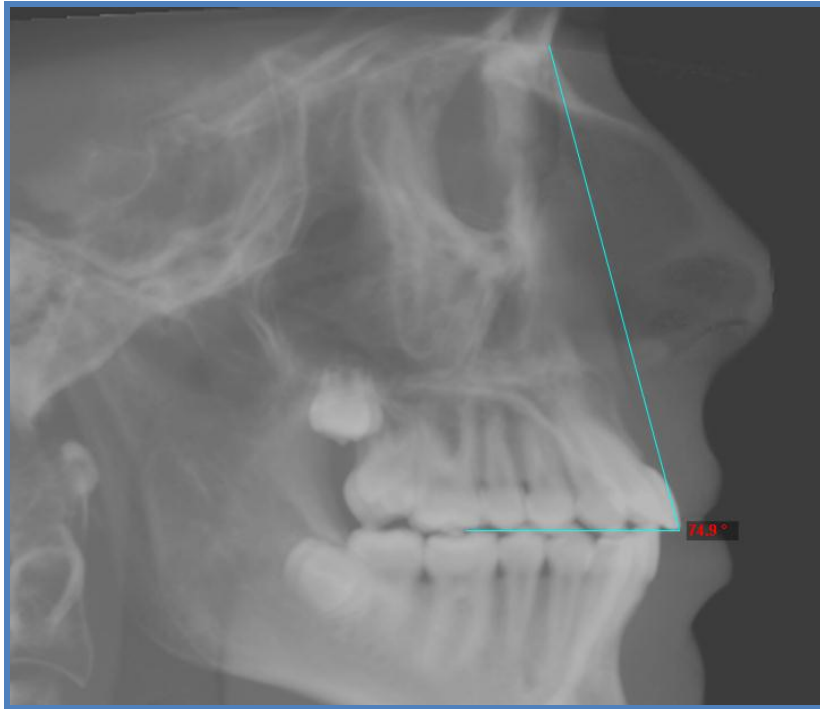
Example of an occlusal plane measure for the lateral view. Segmentation of the radiograph and placement of reference lines for the localization of the maxillary right first molar mesio-buccal cusp tip and maxillary right central incisal tip was completed prior to the final measurement angle to nasion. This image is from a final CBCT after removal of appliances.
